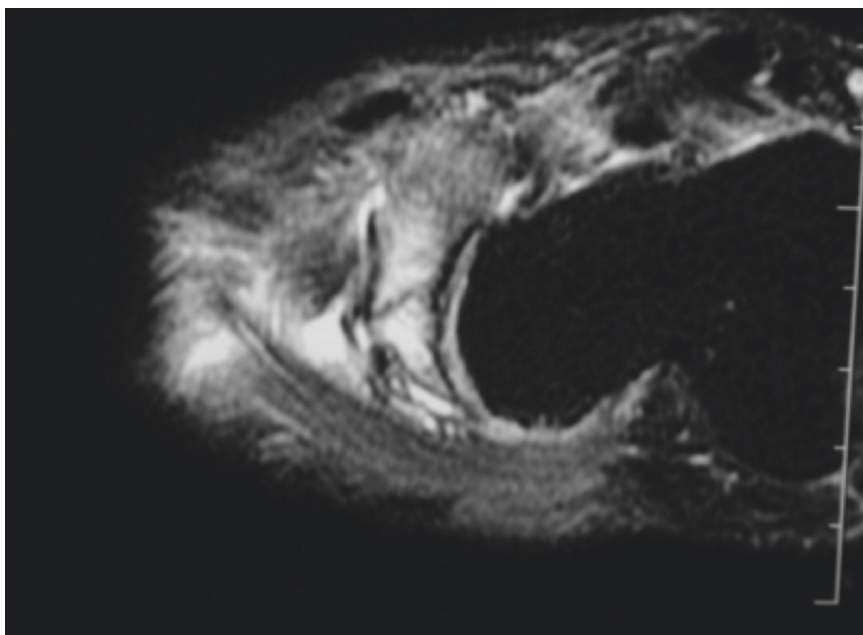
T2-weighted MRI images of a stress fracture of the navicular demonstrating increased signal within the marrow and in the surrounding soft tissue
